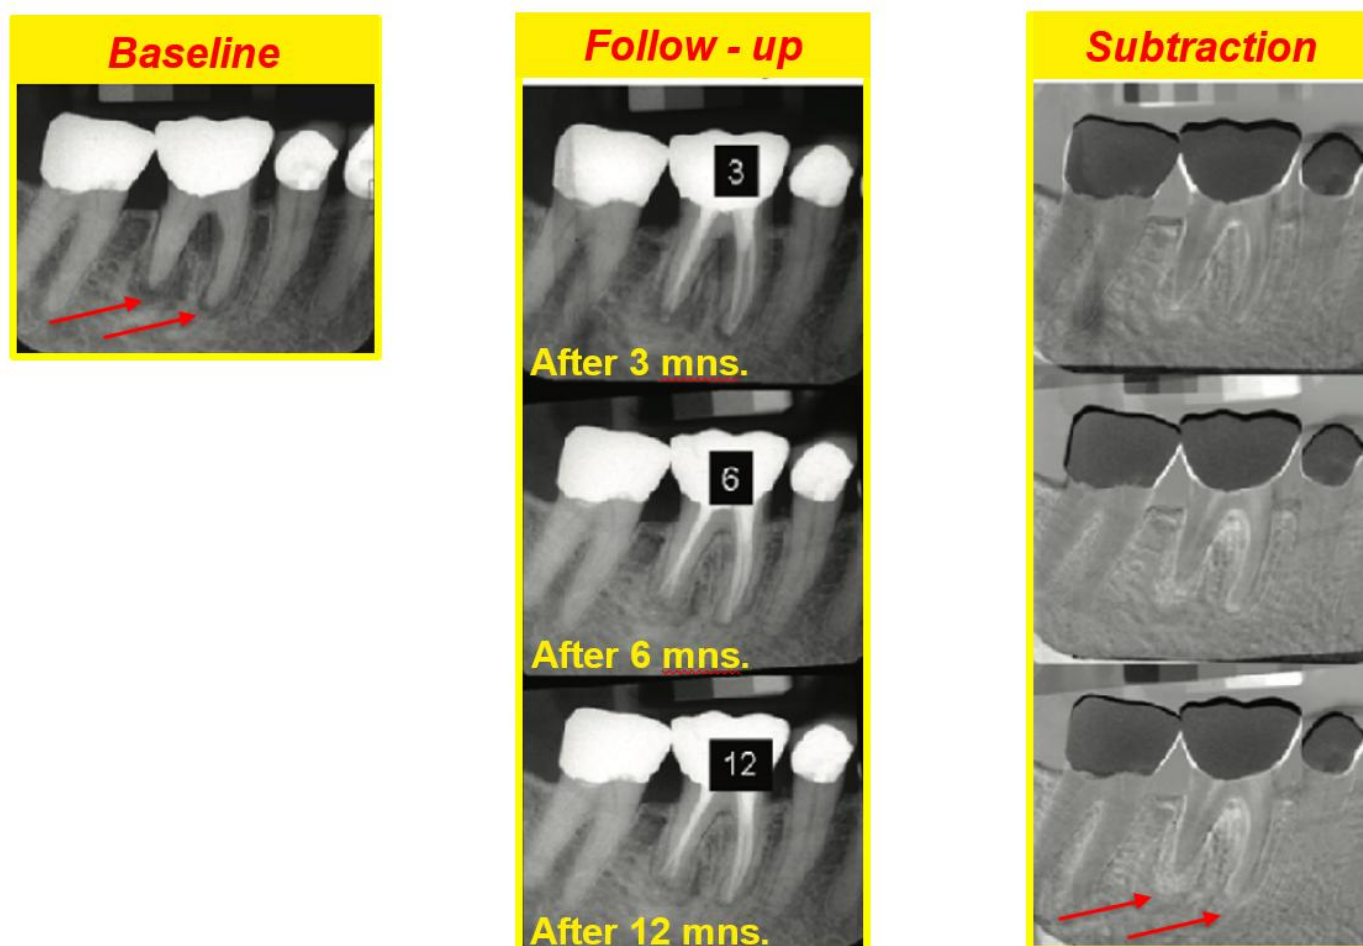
Digital subtraction comparing baseline (column 1) to follow-up images (column 2). Column 3 indicates subtraction of respective follow-up images from the baseline radiograph. Progressive remineralization of the radiolucency at the apex of the distal root of the 1st molar is evident.
